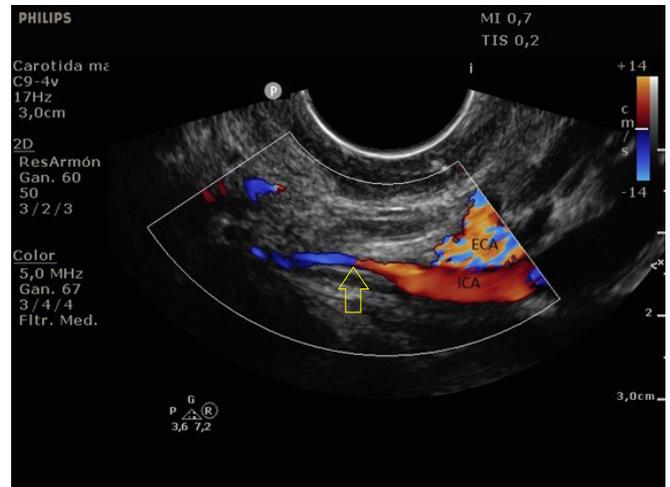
Transoral ultrasonography. Yellow arrow; homogeneous hypoechoic image with absence of Doppler signal compatible with false lumen thrombosis and refinement of the true lumen.
